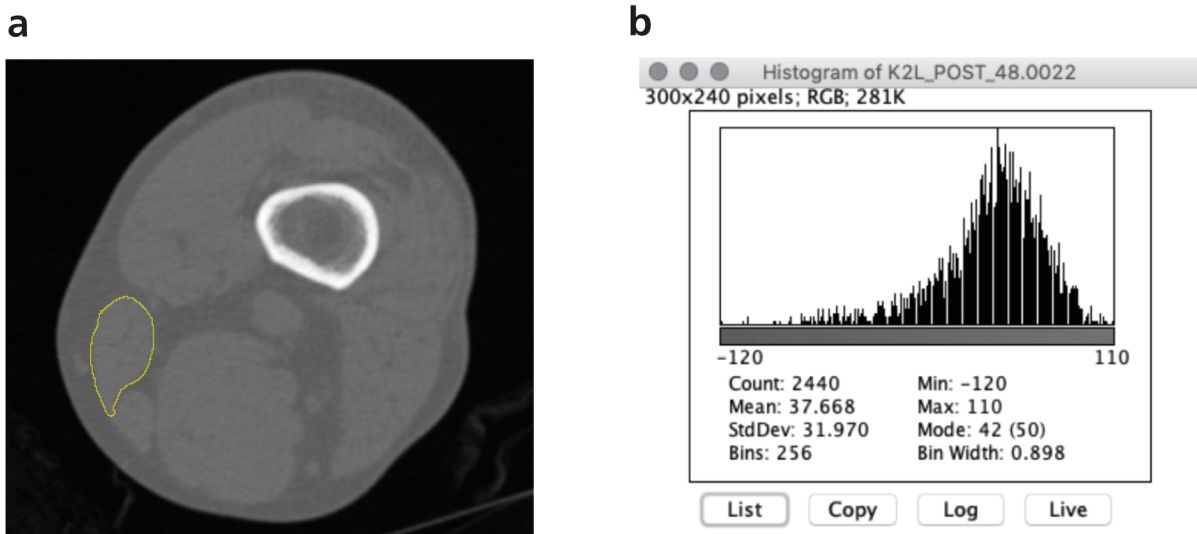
Segmentation of muscle tissue. Postoperative axial CT slice with manual segmentation of the sartorius muscle in yellow (a). The the pixel distribution is represented as a histogram (b).
